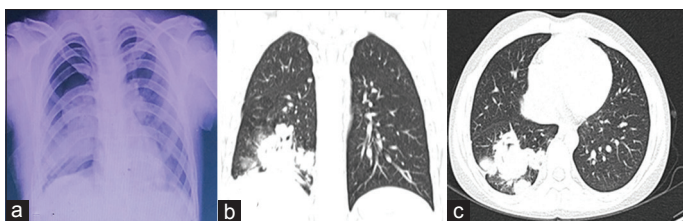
(a) Chest X-ray after deterioration and (b) repeat high-resolution computed tomography chest were suggestive of the irregular lesion in the apical region of the right lower lobe. These findings were suggestive of progression of the disease
